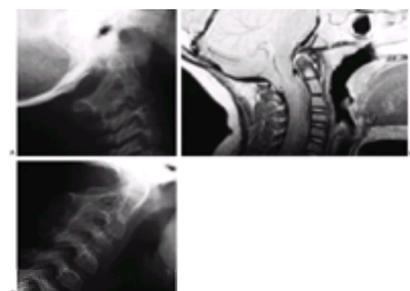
This 3-year, 9-month-old girl had a history of vertex headaches for 1 year. One month before presentation she developed a painful, left-sided torticollis. A: Plain lateral radiograph shows fusion of C2-C3 and absence of the ring of C1 with occipitalization. B: The magnetic resonance image shows an Arnold-Chiari malformation, with herniation of the cerebellar tonsils into the foramen magnum (arrow). Also note the cordal edema (arrowhead). C: The child underwent occipital decompression and laminectomy to C3, posterior cervical fusion from the occiput to C4, and halo cast immobilization for 4 months. Flexion and extension lateral radiographs 1 year after treatment show solid incorporation of the fusion from C2 to C4, with dissolution of the graft from the occiput to C2. However, there is no atlantooccipital instability. The child's symptoms resolved.
